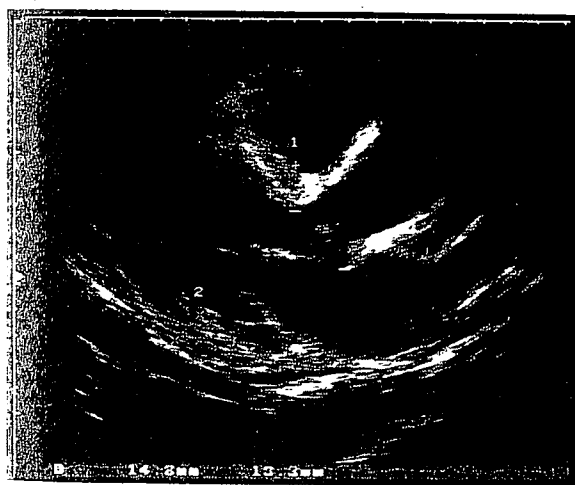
Echocardiogram on admission showed left ventricular hypertrophy and dilatation with normal contractility, left atrial dilatation, and mild pericardial effusion. Interventricular septal thickness: 14 mm, left ventricular posterior wall thickness: 13 mm, left ventricular end-diastolic diameter: 53 mm, left ventricular end-systolic diameter: 29 mm, left atrial diameter: 53 mm.
